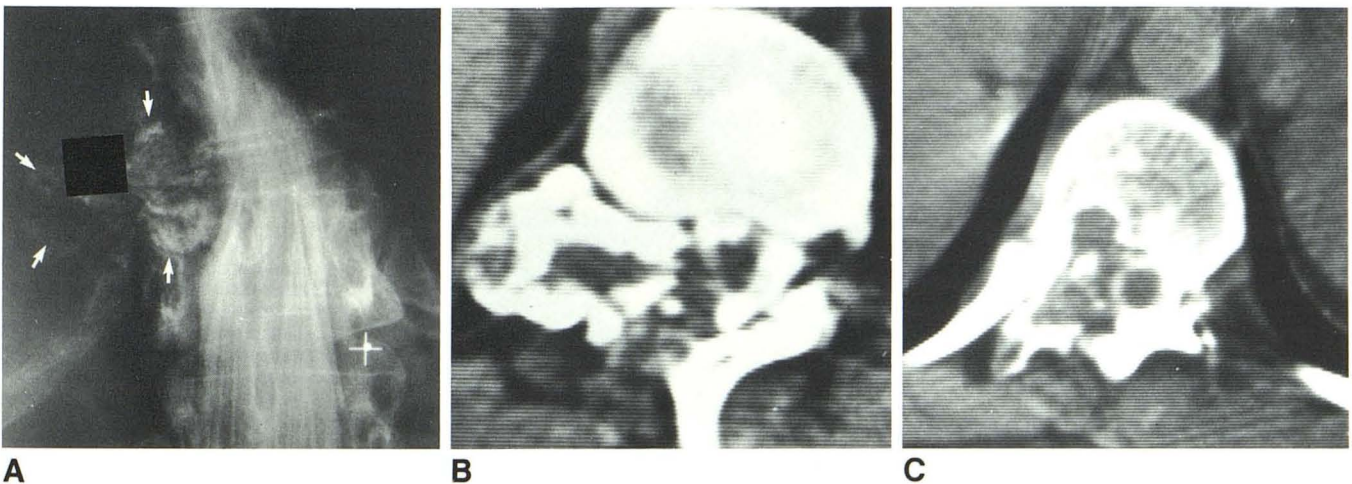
A, Well defined, calcified, intra- and paraspinal mass (arrows) with destruction of T11 pedicle and compression of spinal cord. B, CT myelogram at level of lesion. Intra- and paraspinal mass is well delineated. Marked widening
